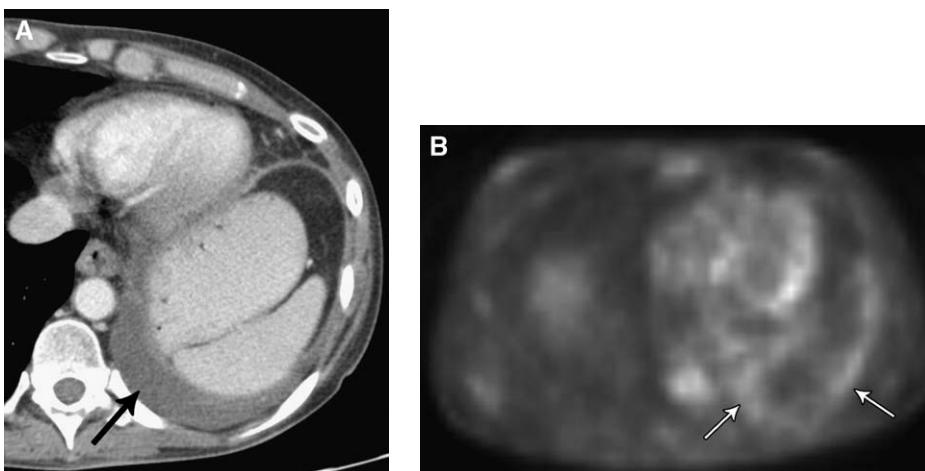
A 46-year-old woman with metastatic adenocarcinoma of the lung. (A) CT scan shows a left pleural effusion (*arrow*) with no evidence for pleural nodularity or enhancement. (B) FDG-PET scan shows increase uptake in the pleural space (*arrows*). The effusion was metastatic on cytology.
